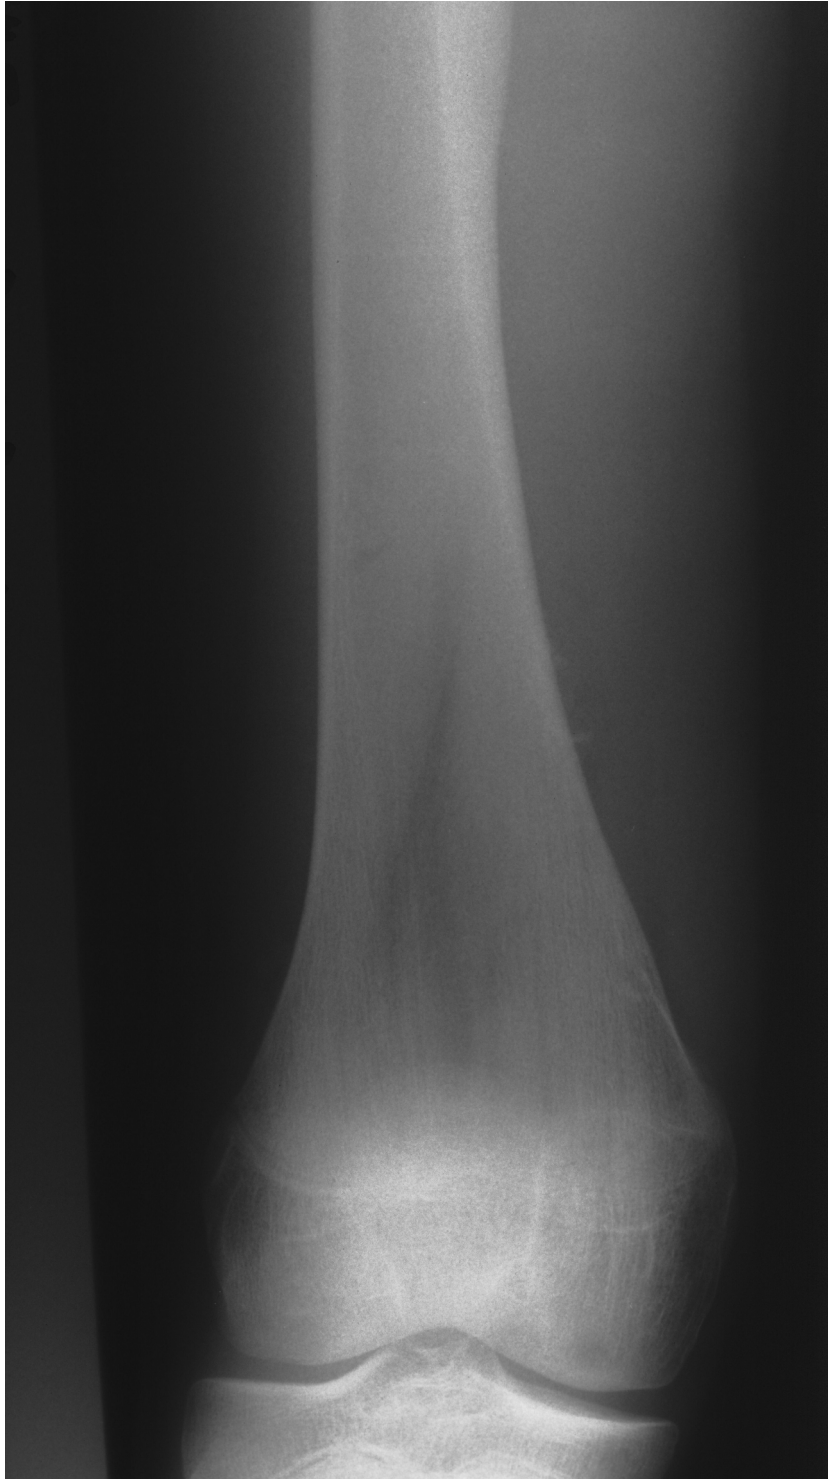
Radiographs at 1 year follow-up.
